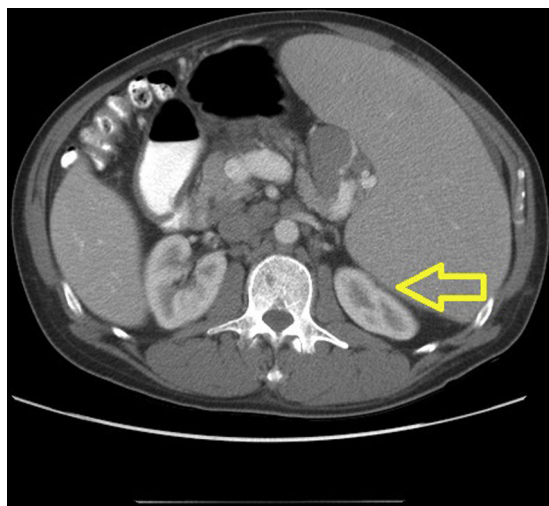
A 58-year-old man with massive splenomegaly. Axial contrast-enhanced CT of the abdomen showing splenomegaly with compression of the left renal parenchyma (arrow).
